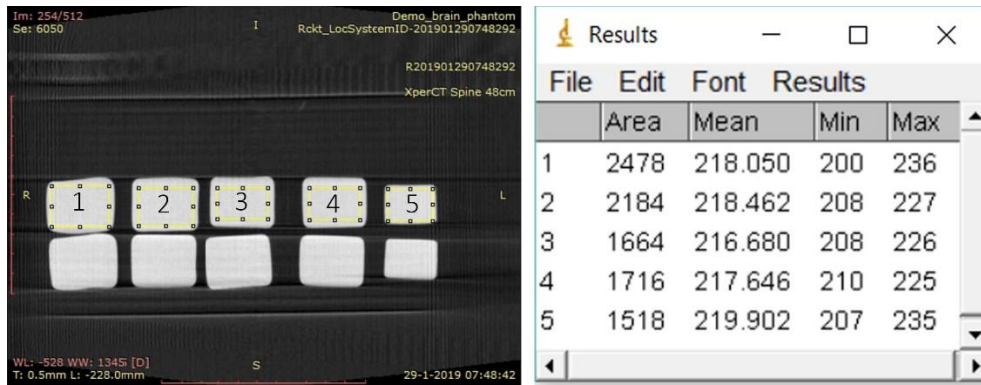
DIFFERENT CONCENTRATIONS OF COOLANT ASSESSED ON INFLUENCE IN GRAYSCALE IN IMAGING WITH CT
